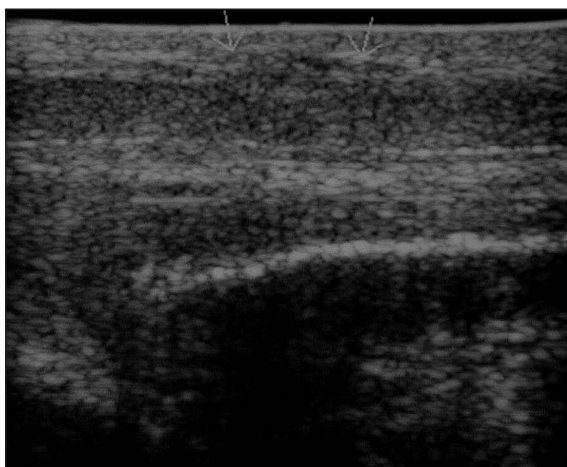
Less common variant of PD showing a hypoechoic lesion of the dorsal tunica albuginea without acoustic attenuation or acoustic enhancement (arrows). Longitudinal sonogram of the left corpus spongiosum.
